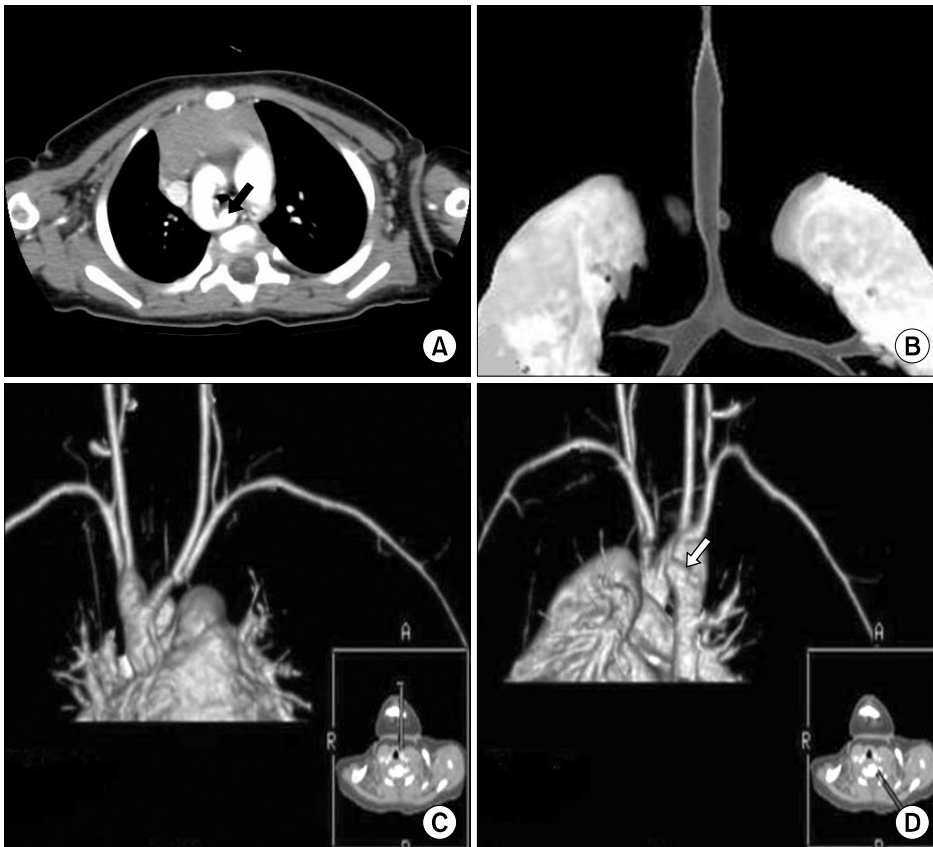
Preoperative computed tomography scans. (A) Kommerell's diverticulum (black arrow) originated from isthmus portion of the right aortic arch. (B) 3-Dimensional image of trachea shows tracheal stenosis above carina. (C) Anterior view of the aortic arch and branches shows a mirror-image branching pattern. (D) Posterior view of aortic arch shows Kommerell's diverticulum (white arrow) at aortic isthmus.
